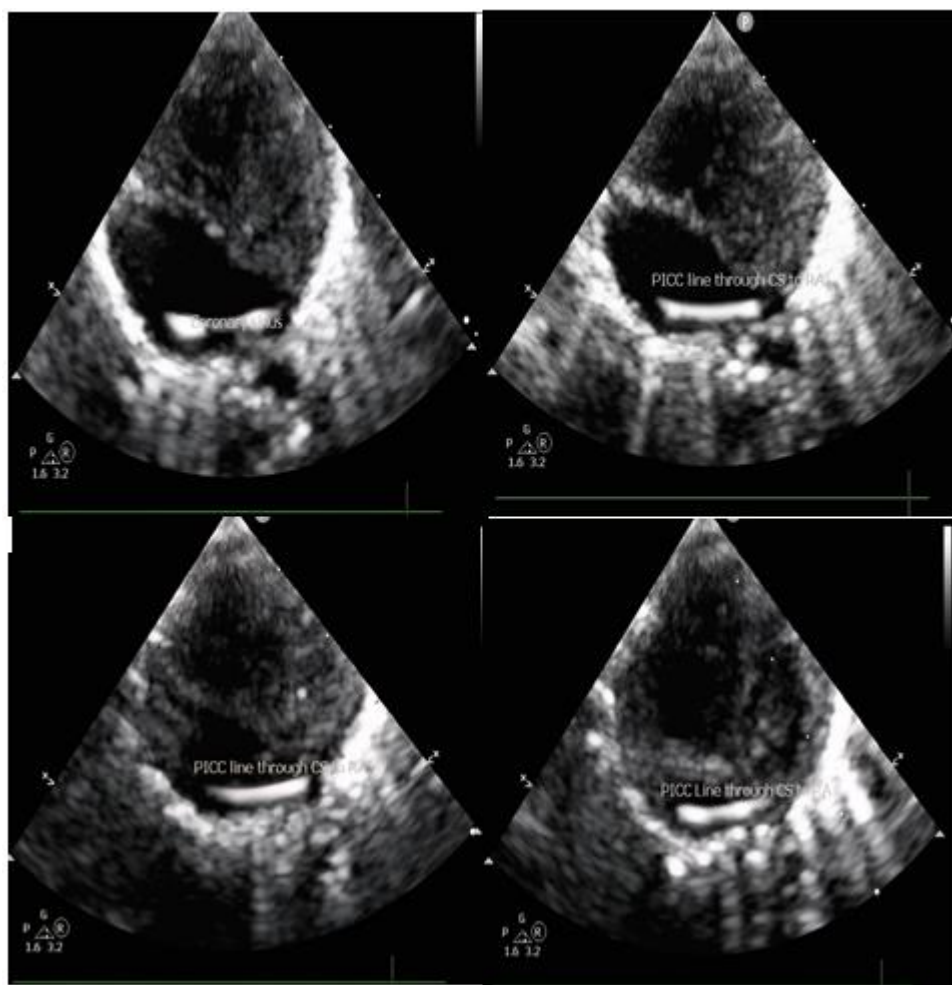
Echocardiograph:Apical four chamber views showing dilated coronary sinus and PICC which can be seen in the right atrium coming through the dialted coronary sinus.
